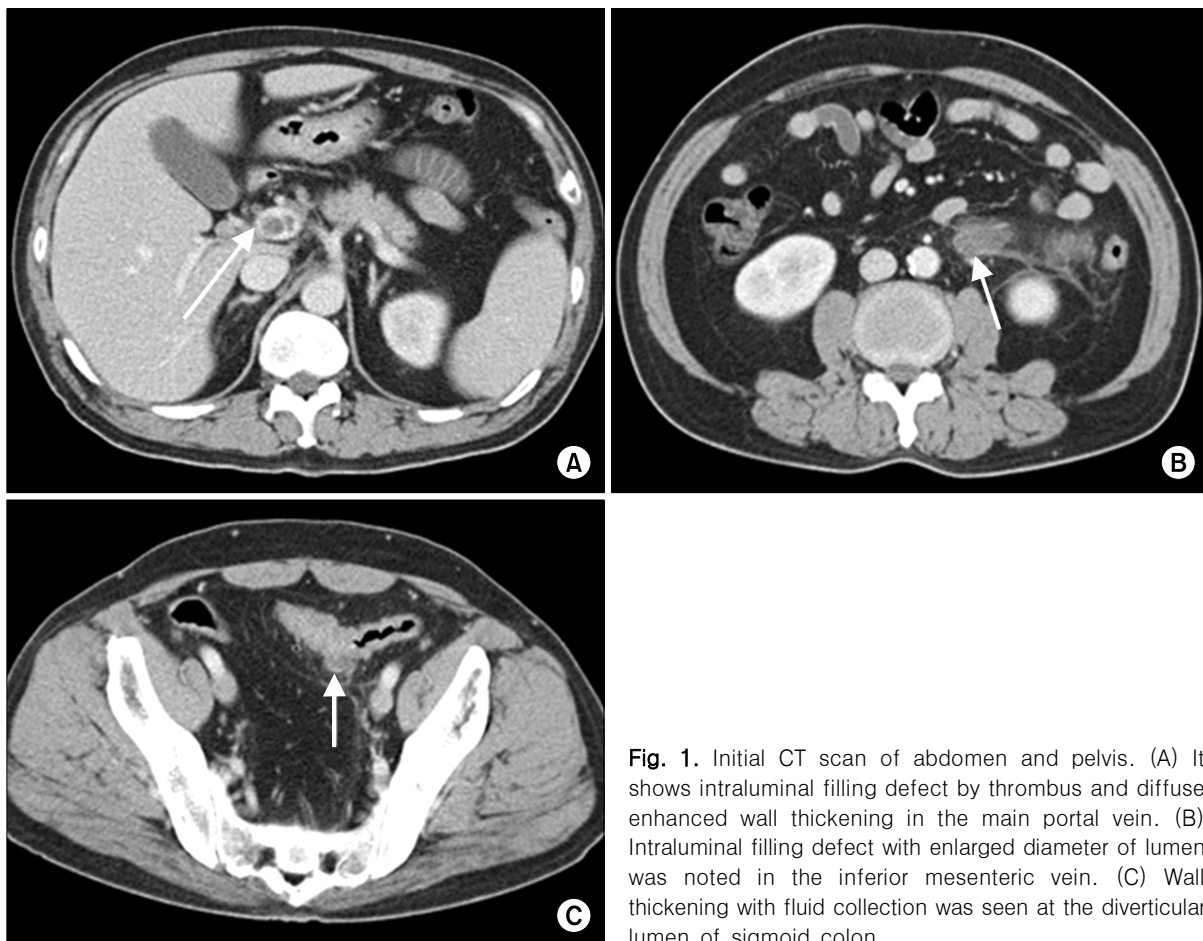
Initial CT scan of abdomen and pelvis. (A) It shows intraluminal filling defect by thrombus and diffuse enhanced wall thickening in the main portal vein. (B) Intraluminal filling defect with enlarged diameter of lumen was noted in the inferior mesenteric vein. (C) Wall thickening with fluid collection was seen at the diverticular lumen of sigmoid colon.
